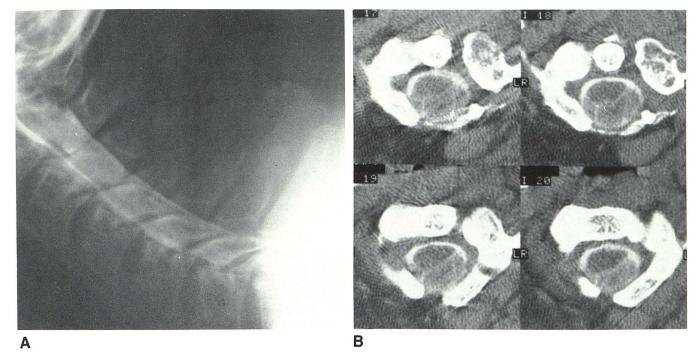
Tonsillar ectopia. A, Metrizamide myelogram reveals posterior foramen magnum mass. B, CT metrizamide myelogram identifies etiology as tonsillar ectopia.
